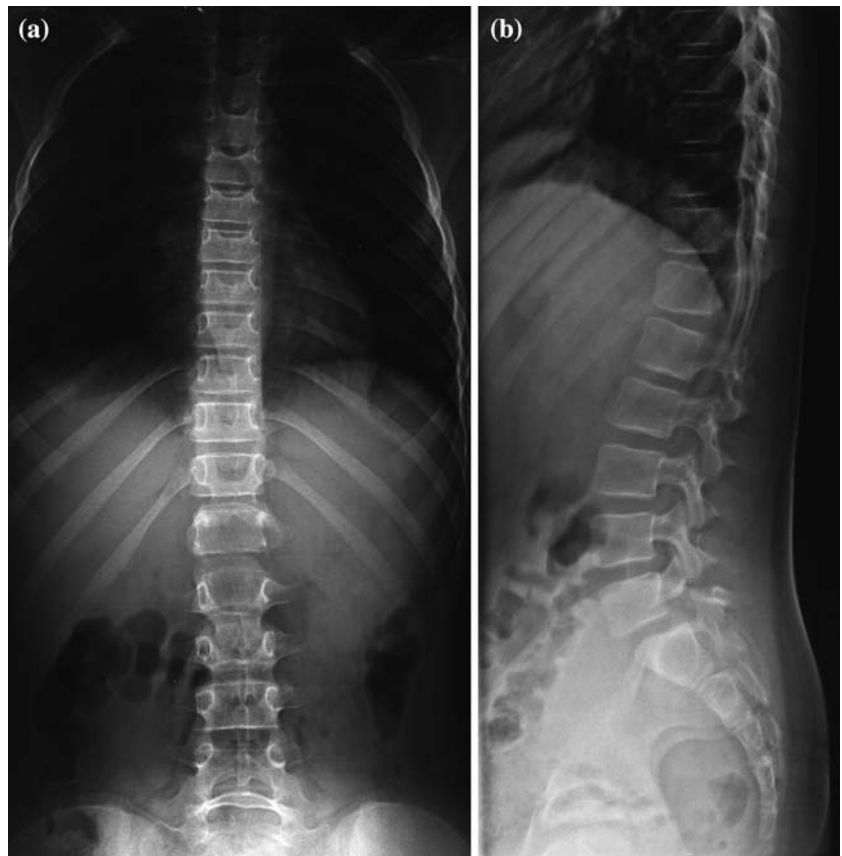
Anteroposterior (a) and anterolateral (b) radiograph in a standing position show the correct alignment of the spine 4 years after the surgery
